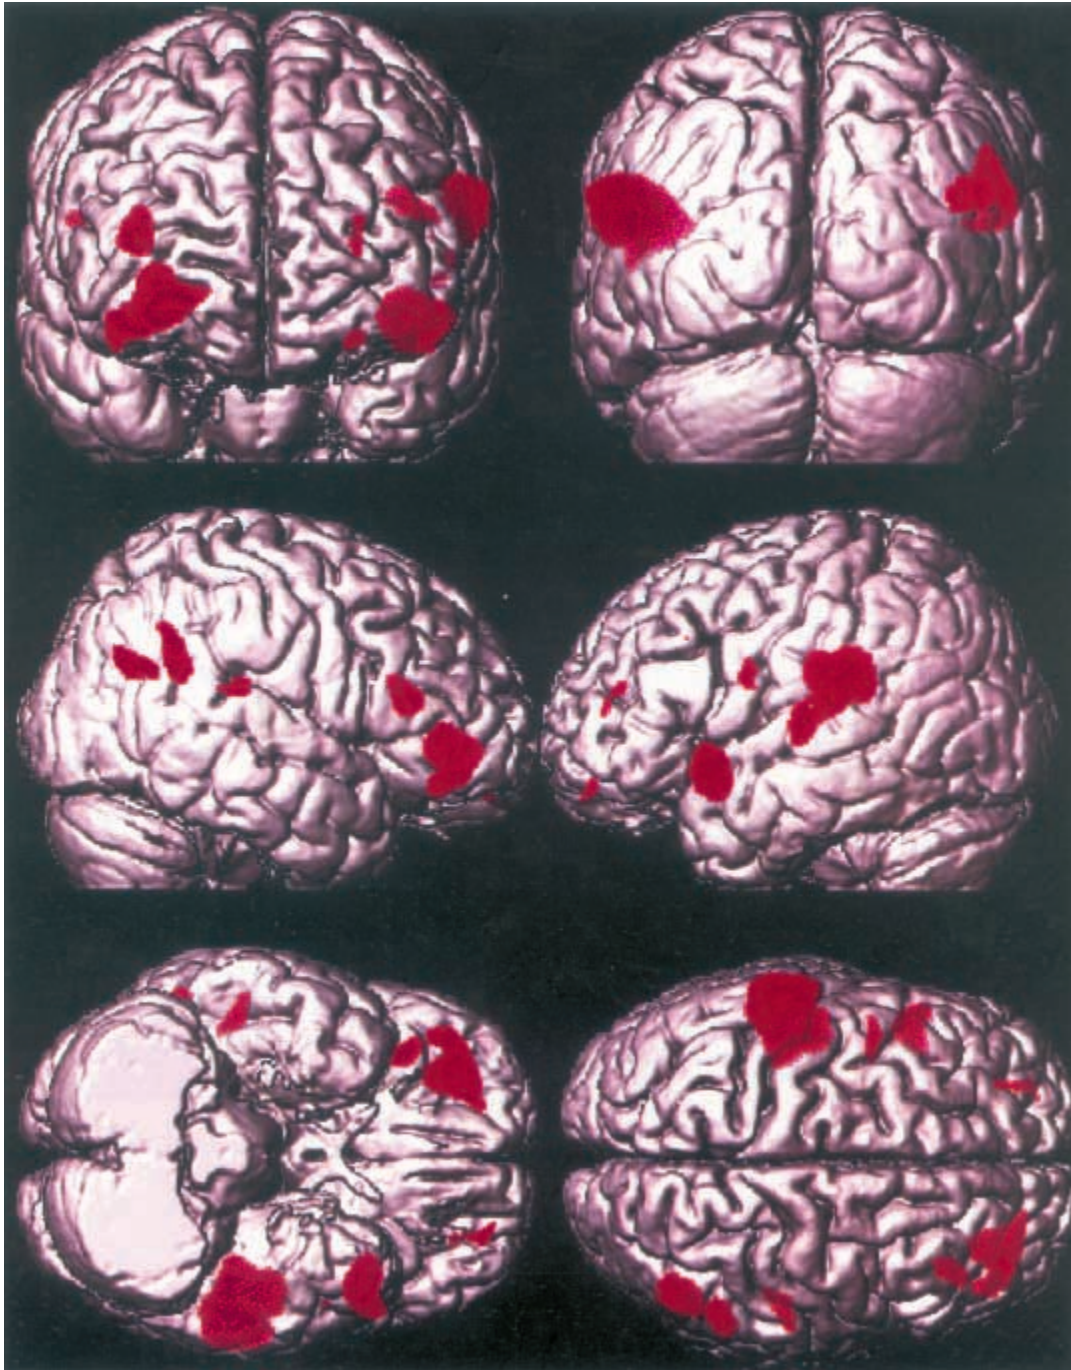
Ictal FDG-PET of the brain during a failed attempt to discontinue anesthesia as treatment of SE.
